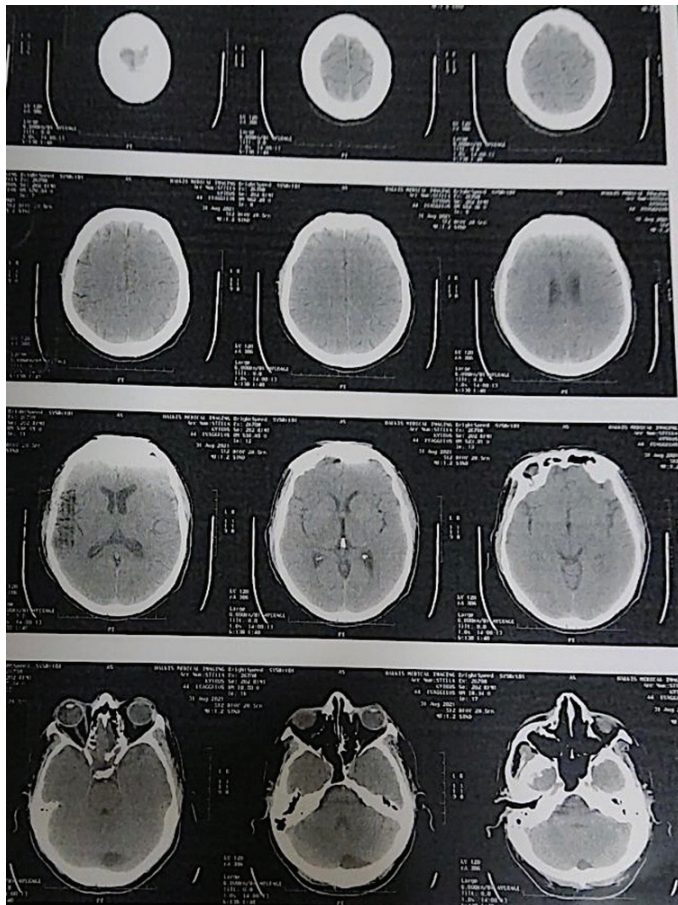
Head CT one month post conservative treatment depicting regression of Pneumocephalus and subcutaneous emphysema
